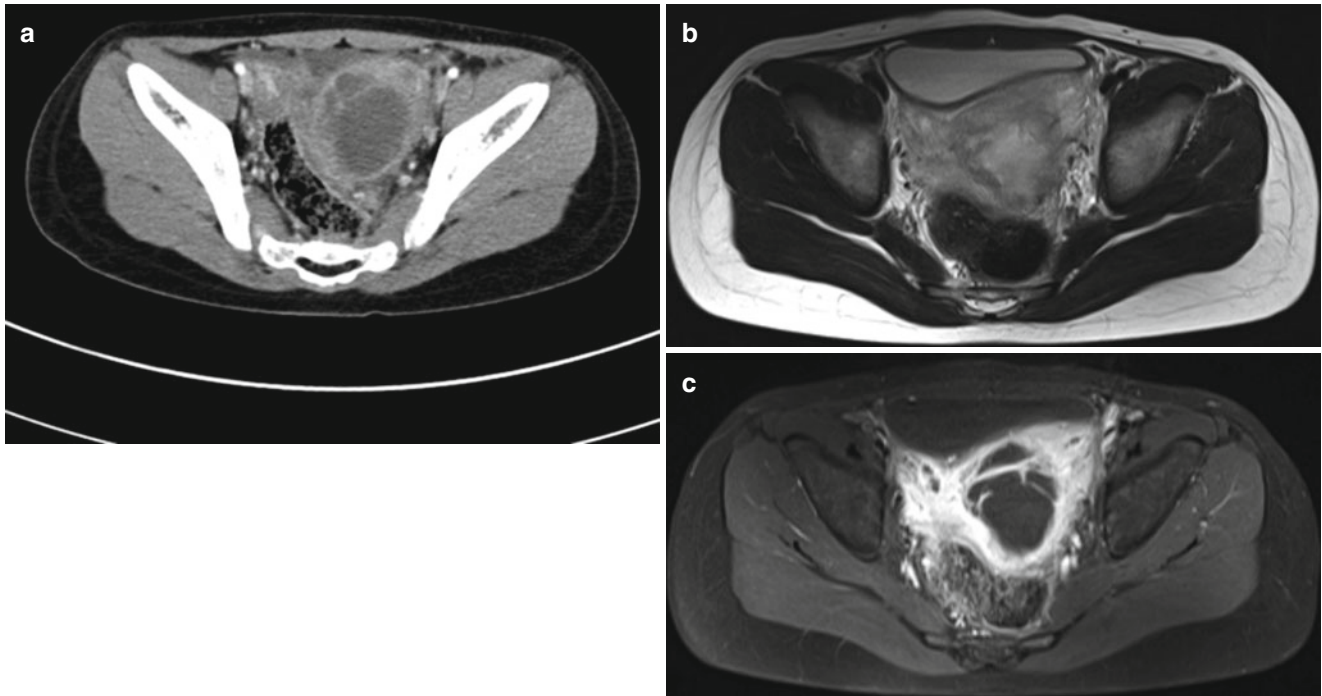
Left tubo-ovarian abscess in an 11-year-old girl. (a) Contrast-enhanced CT scan shows a large cystic mass in left adnexa. This mass has thick wall and septa, and has poor demarcation from the adjacent organs, suggesting adhesion with the uterus and rectosigmoid
